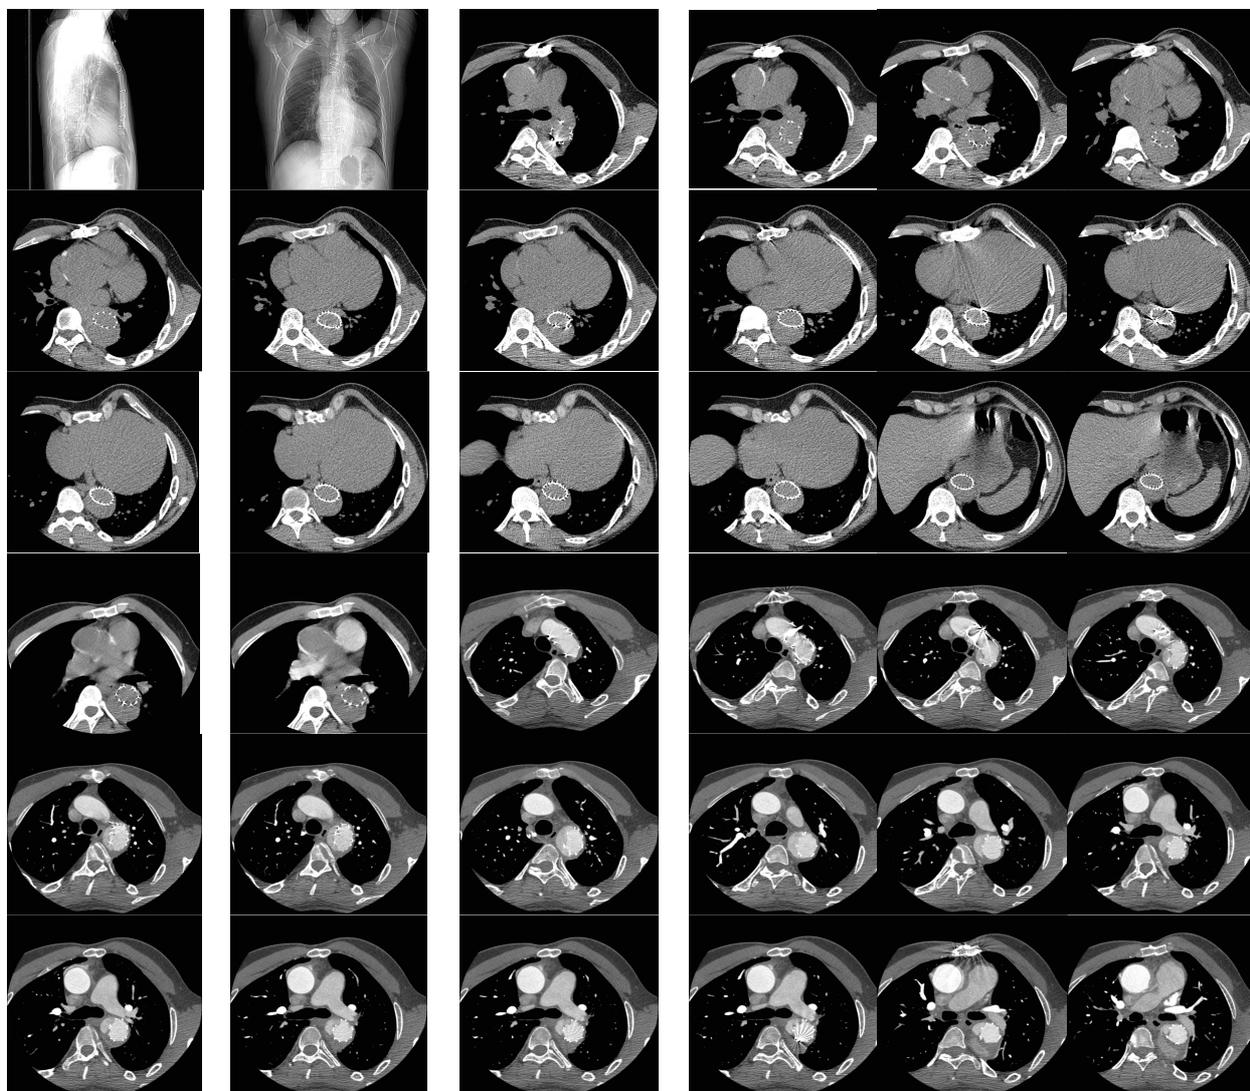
Computed tomography angiography after stent implantation
